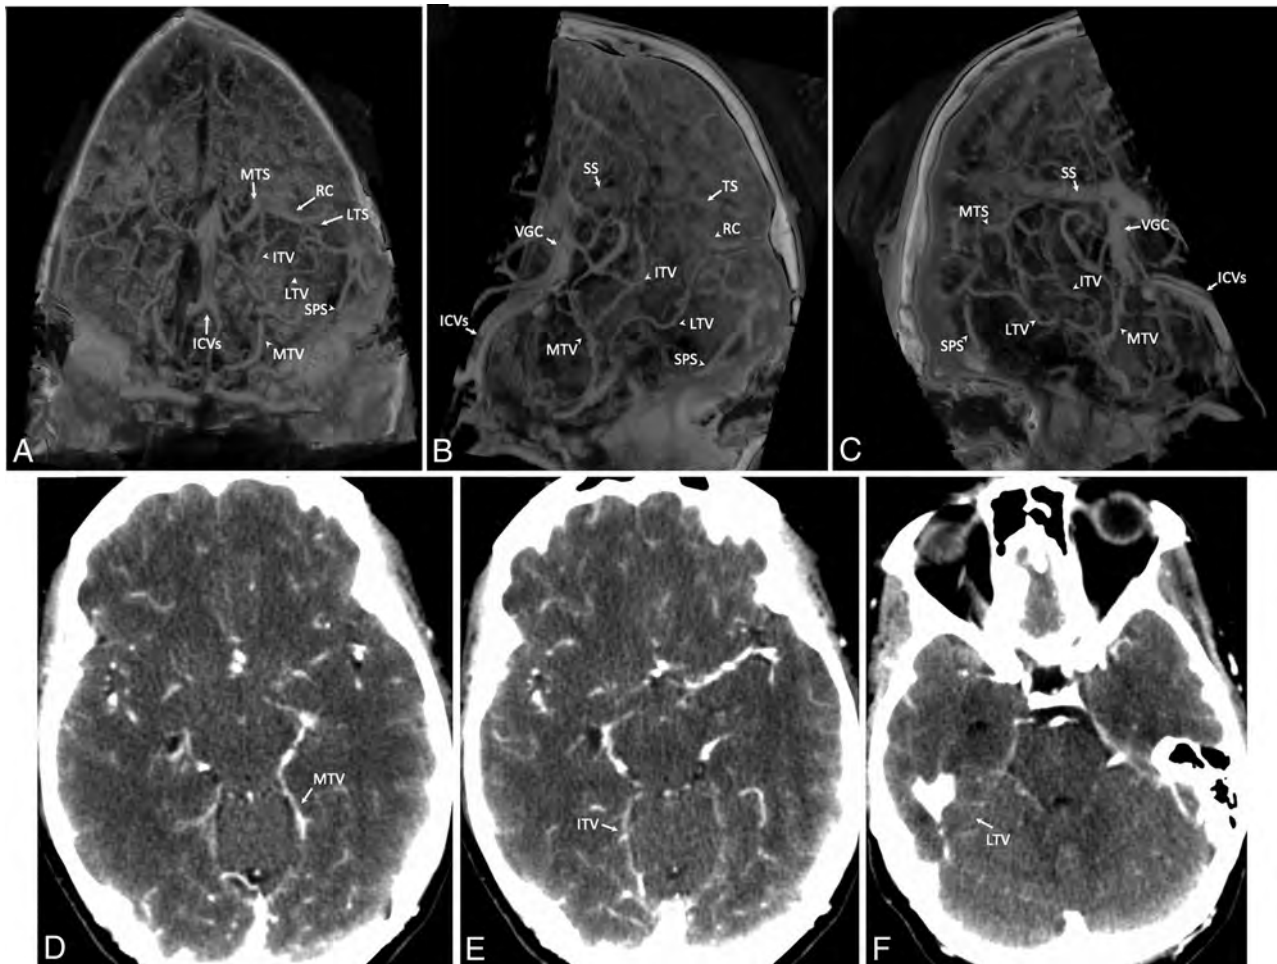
Transtentorial veins. A–C, 3D volumetric reconstruction of delayed-phase CTA of the head and neck; parenchyma (0–40 HU) has been segmented out, leaving the intracranial vessels filled with contrast. A, Reconstructed volume of the head is shown from the anteroposterior view with a 30° downward rotation to show the plane of the tentorium. B, The same reconstruction as in A is rotated to show the left side. C, The same reconstruction rotated to show the right side, which is symmetric. D–F, Source axial images for the volumetric reconstruction of this scan are shown; MTV, ITV, and LTV are labeled. ICV indicates the internal cerebral vein; SS, straight sinus; SPS, superior petrosal sinus; VGC, vein of Galen confluens; TS, transverse sinus; MTV, medial tentorial sinus.
